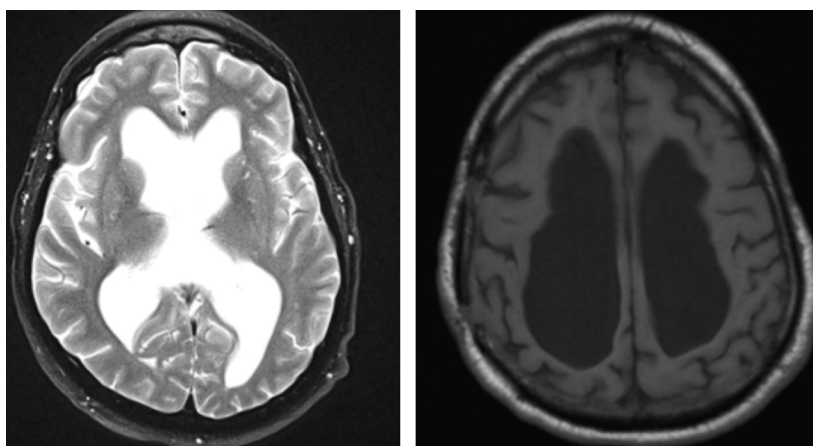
MRI axial sequences 5 months after drainage without chSDH.
